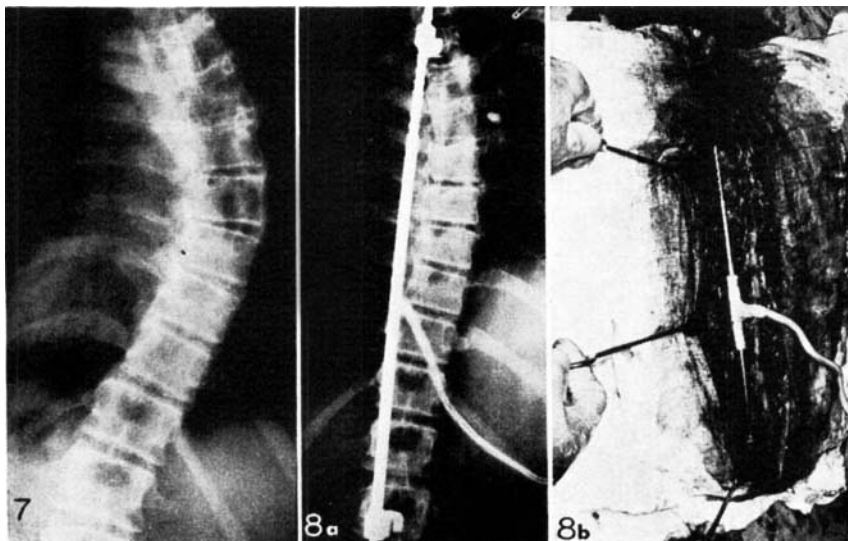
Erect roentgenogram of Patient 2.
